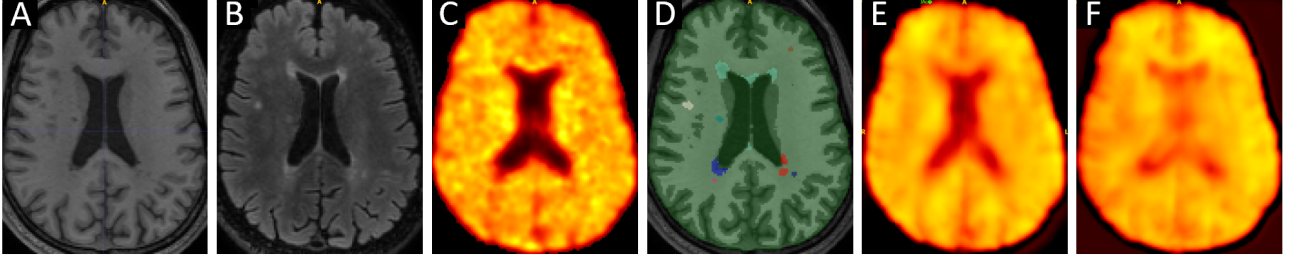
On the same testing patient, A: T1w, B: FLAIR, C: True PiB DVR, D: different Regions of Interest (brain mask in green, white matter in white, lesions in different colors), E: synthetic PiB DVR from curricular training, F: synthetic PiB DVR from anti-curricular training.
